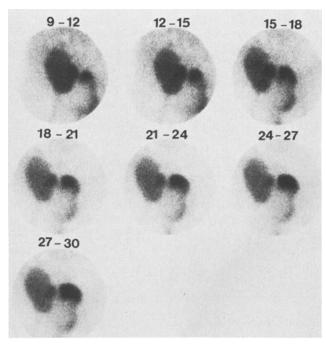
Lymphocele displacing ureter to right and bladder to left. Post-void scintigram (not shown here) demonstrates emptying of activity from distorted bladder.
